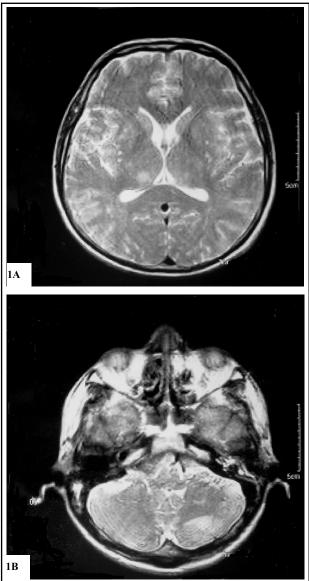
The T2 W images of brain MRI of the patient show multiple hyperintense foci on bilateral the medial thalamus (A; thick arrows), and within the cerebellar white matter (B; thin arrows).
